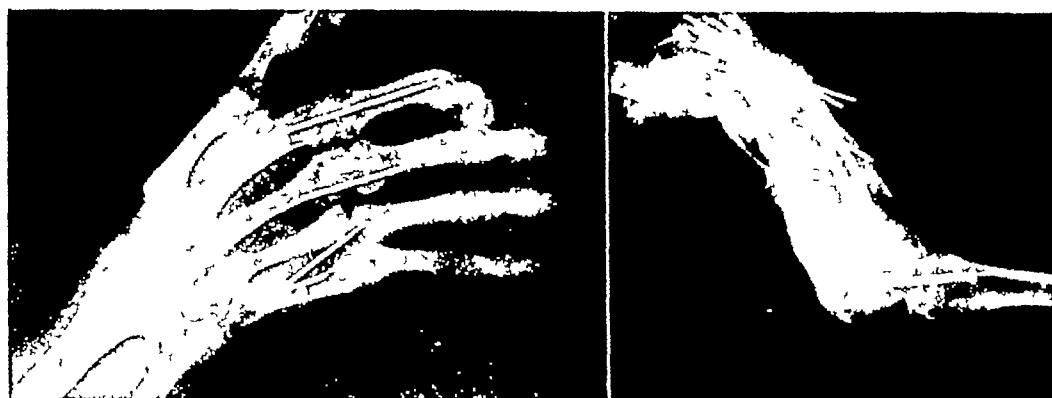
Arthrodesis of wrist and metacarpophalangeal joints of fingers in patient with irreparable median and radial palsy. Wrist fusion done first (after Robinson-Kayfetz), followed by fusion of metacarpophalangeal joints (see p. 778) three months later. Pins gradually worked themselves out. Screw was removed after nine months. This roentgenogram shows result seven months after wrist fusion (four months after metacarpophalangeal joint fusion).
